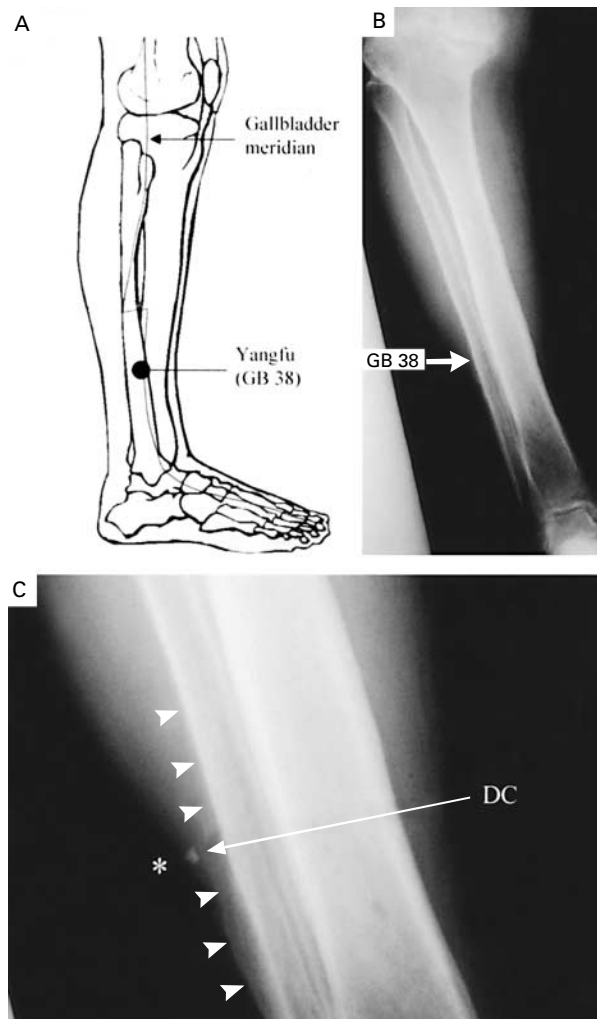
Site of Acupuncture along the Gallbladder Meridian (Panel A) and Anteroposterior Radiographs of the Patient's Right Leg (Panels B and C).
